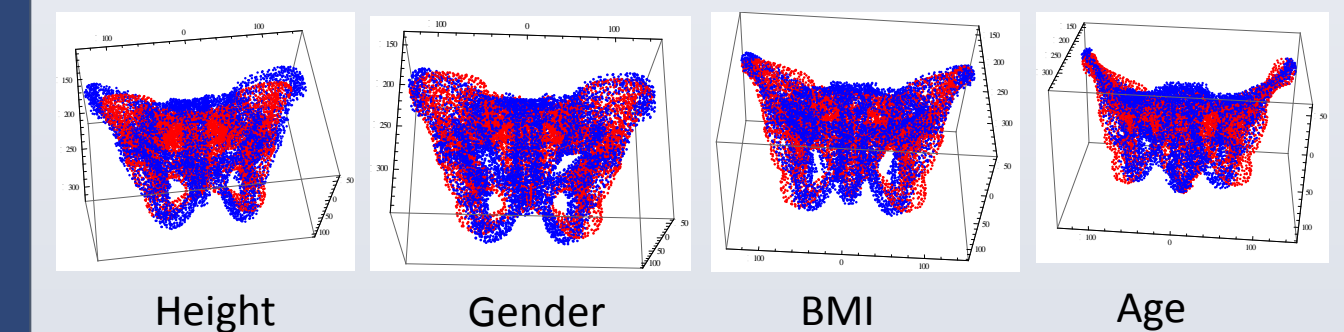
Images showing the effects of varying height, gender, BMI, and age on pelvis shape over the ranges present in the CT dataset while holding other parameters constant.
